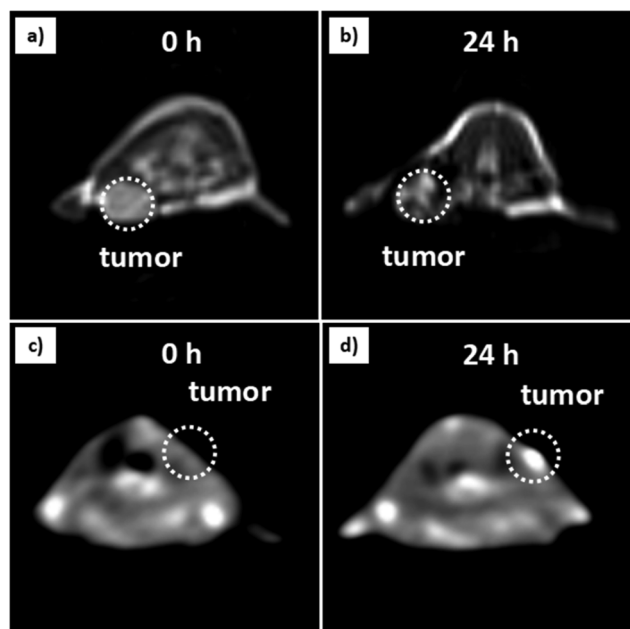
In vivo* (a–b) T_2 -MR and (c–d) coronal CT images of the tumor after intravenous injection of UCNPs-Ce6/PEG before and 24 h after injection, respectively.
